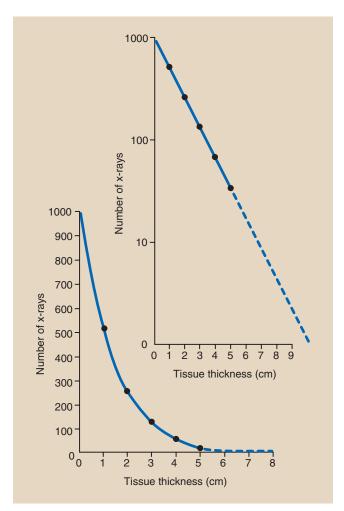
Linear and semilog plots of exponential x-ray attenuation data in Figure 9-15.
